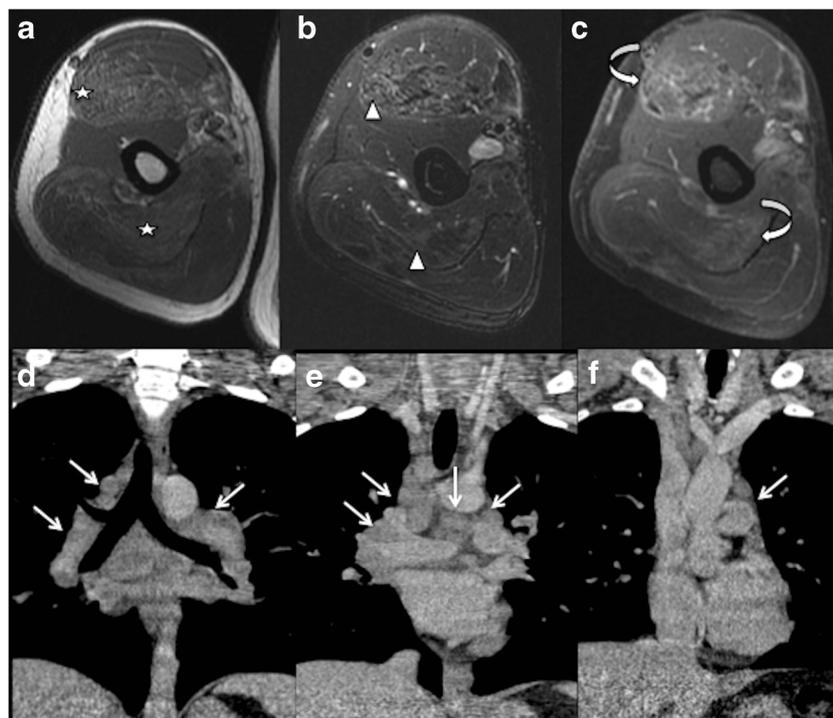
Sarcoidal myopathy. A 29-year-old male with progressive weakness and atrophy of the right arm. FSE axial MR imaging with T1 (a), T2 fat-sat (b), and T1 fat-sat after contrast shows edema (arrow head) and focal areas of fat-infiltration (star) with gadolinium enhancement
